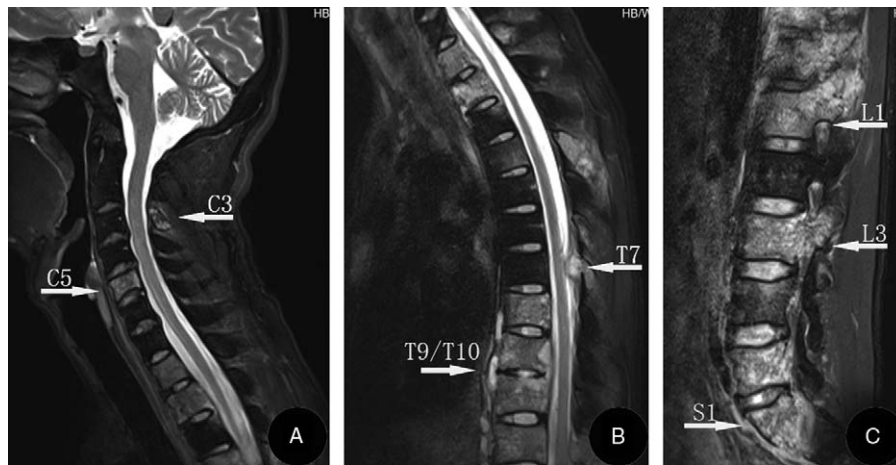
Magnetic resonance imaging (MRI) of the entire spine. Sagittal (A–C) T2-weighted image images STIR showed that heterogeneous mixed high-intensity changes at C3, C5, T1–T5, T7–T12, L1–L5, and S1 segments. Sagittal T2W image STIR showed hyperintensity of L1 and L3 vertebral body with associated heterogeneous signal extending anteriorly into the posterior region. There was also fusiform paraspinous abscess involving the T9/T10 level and small epidural abscess at the posterior of the spinal canal at T7. The disc spaces and height of vertebrae are relatively preserved.
